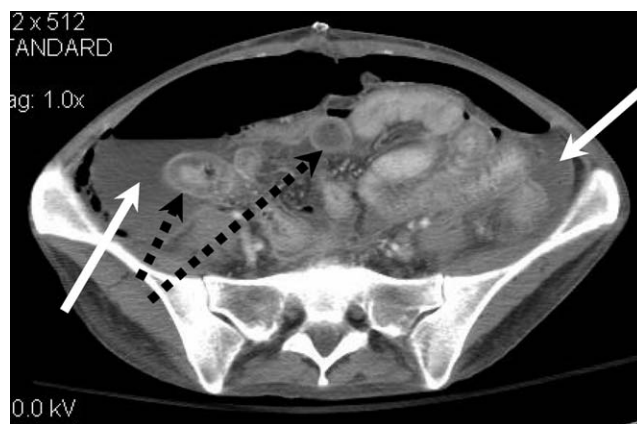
CT scan of a 37-year-old woman, 4 days following an ileocecal resection for Crohn's disease. The CT findings of diffuse intra-peritoneal fluid and free air (white arrows) indicate a process that is not amenable to percutaneous drainage; operative exploration revealed an unrecognized defect in the rectum. Note enhancement of peritoneum overlying loops of small bowel, a further sign of diffuse peritonitis (dashed arrows).
